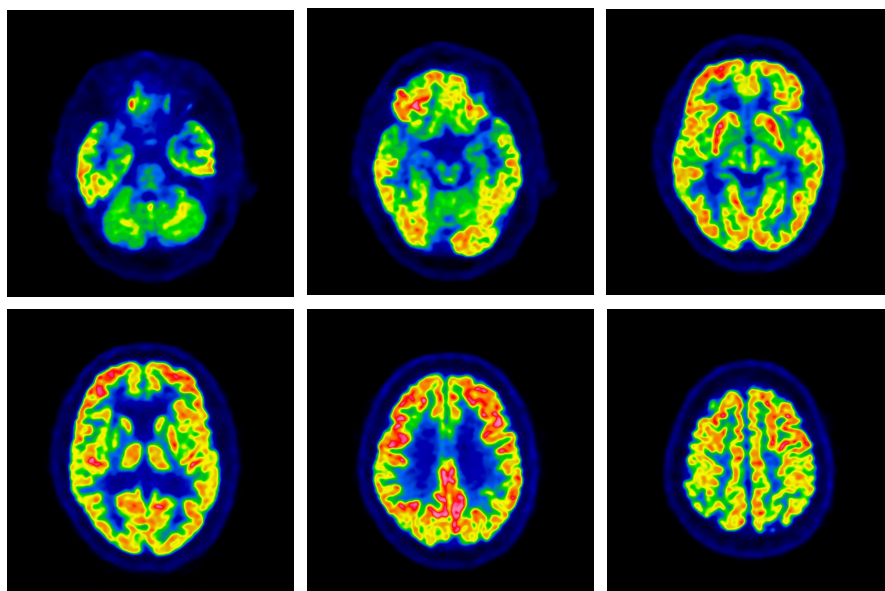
Normal subject. BresTome FDG-PET axial image from cerebellum to thalamus–basal ganglia level. Cortical gyri and the contrast between gray and white matter are clearly depicted.
